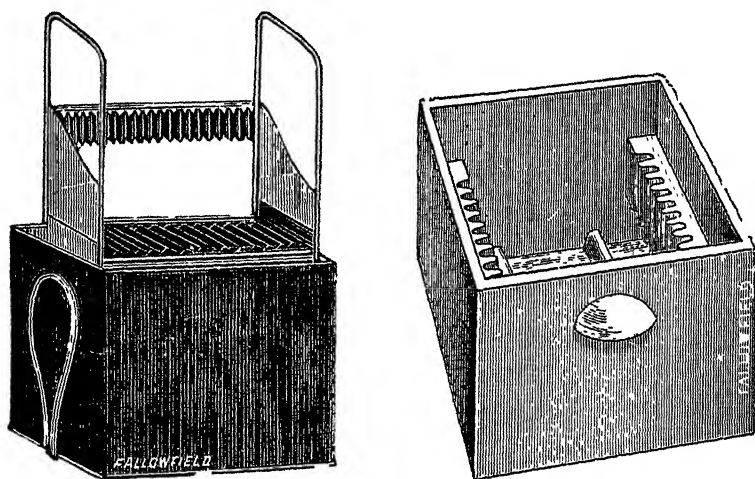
X-RAY PLATE WASHERS.
